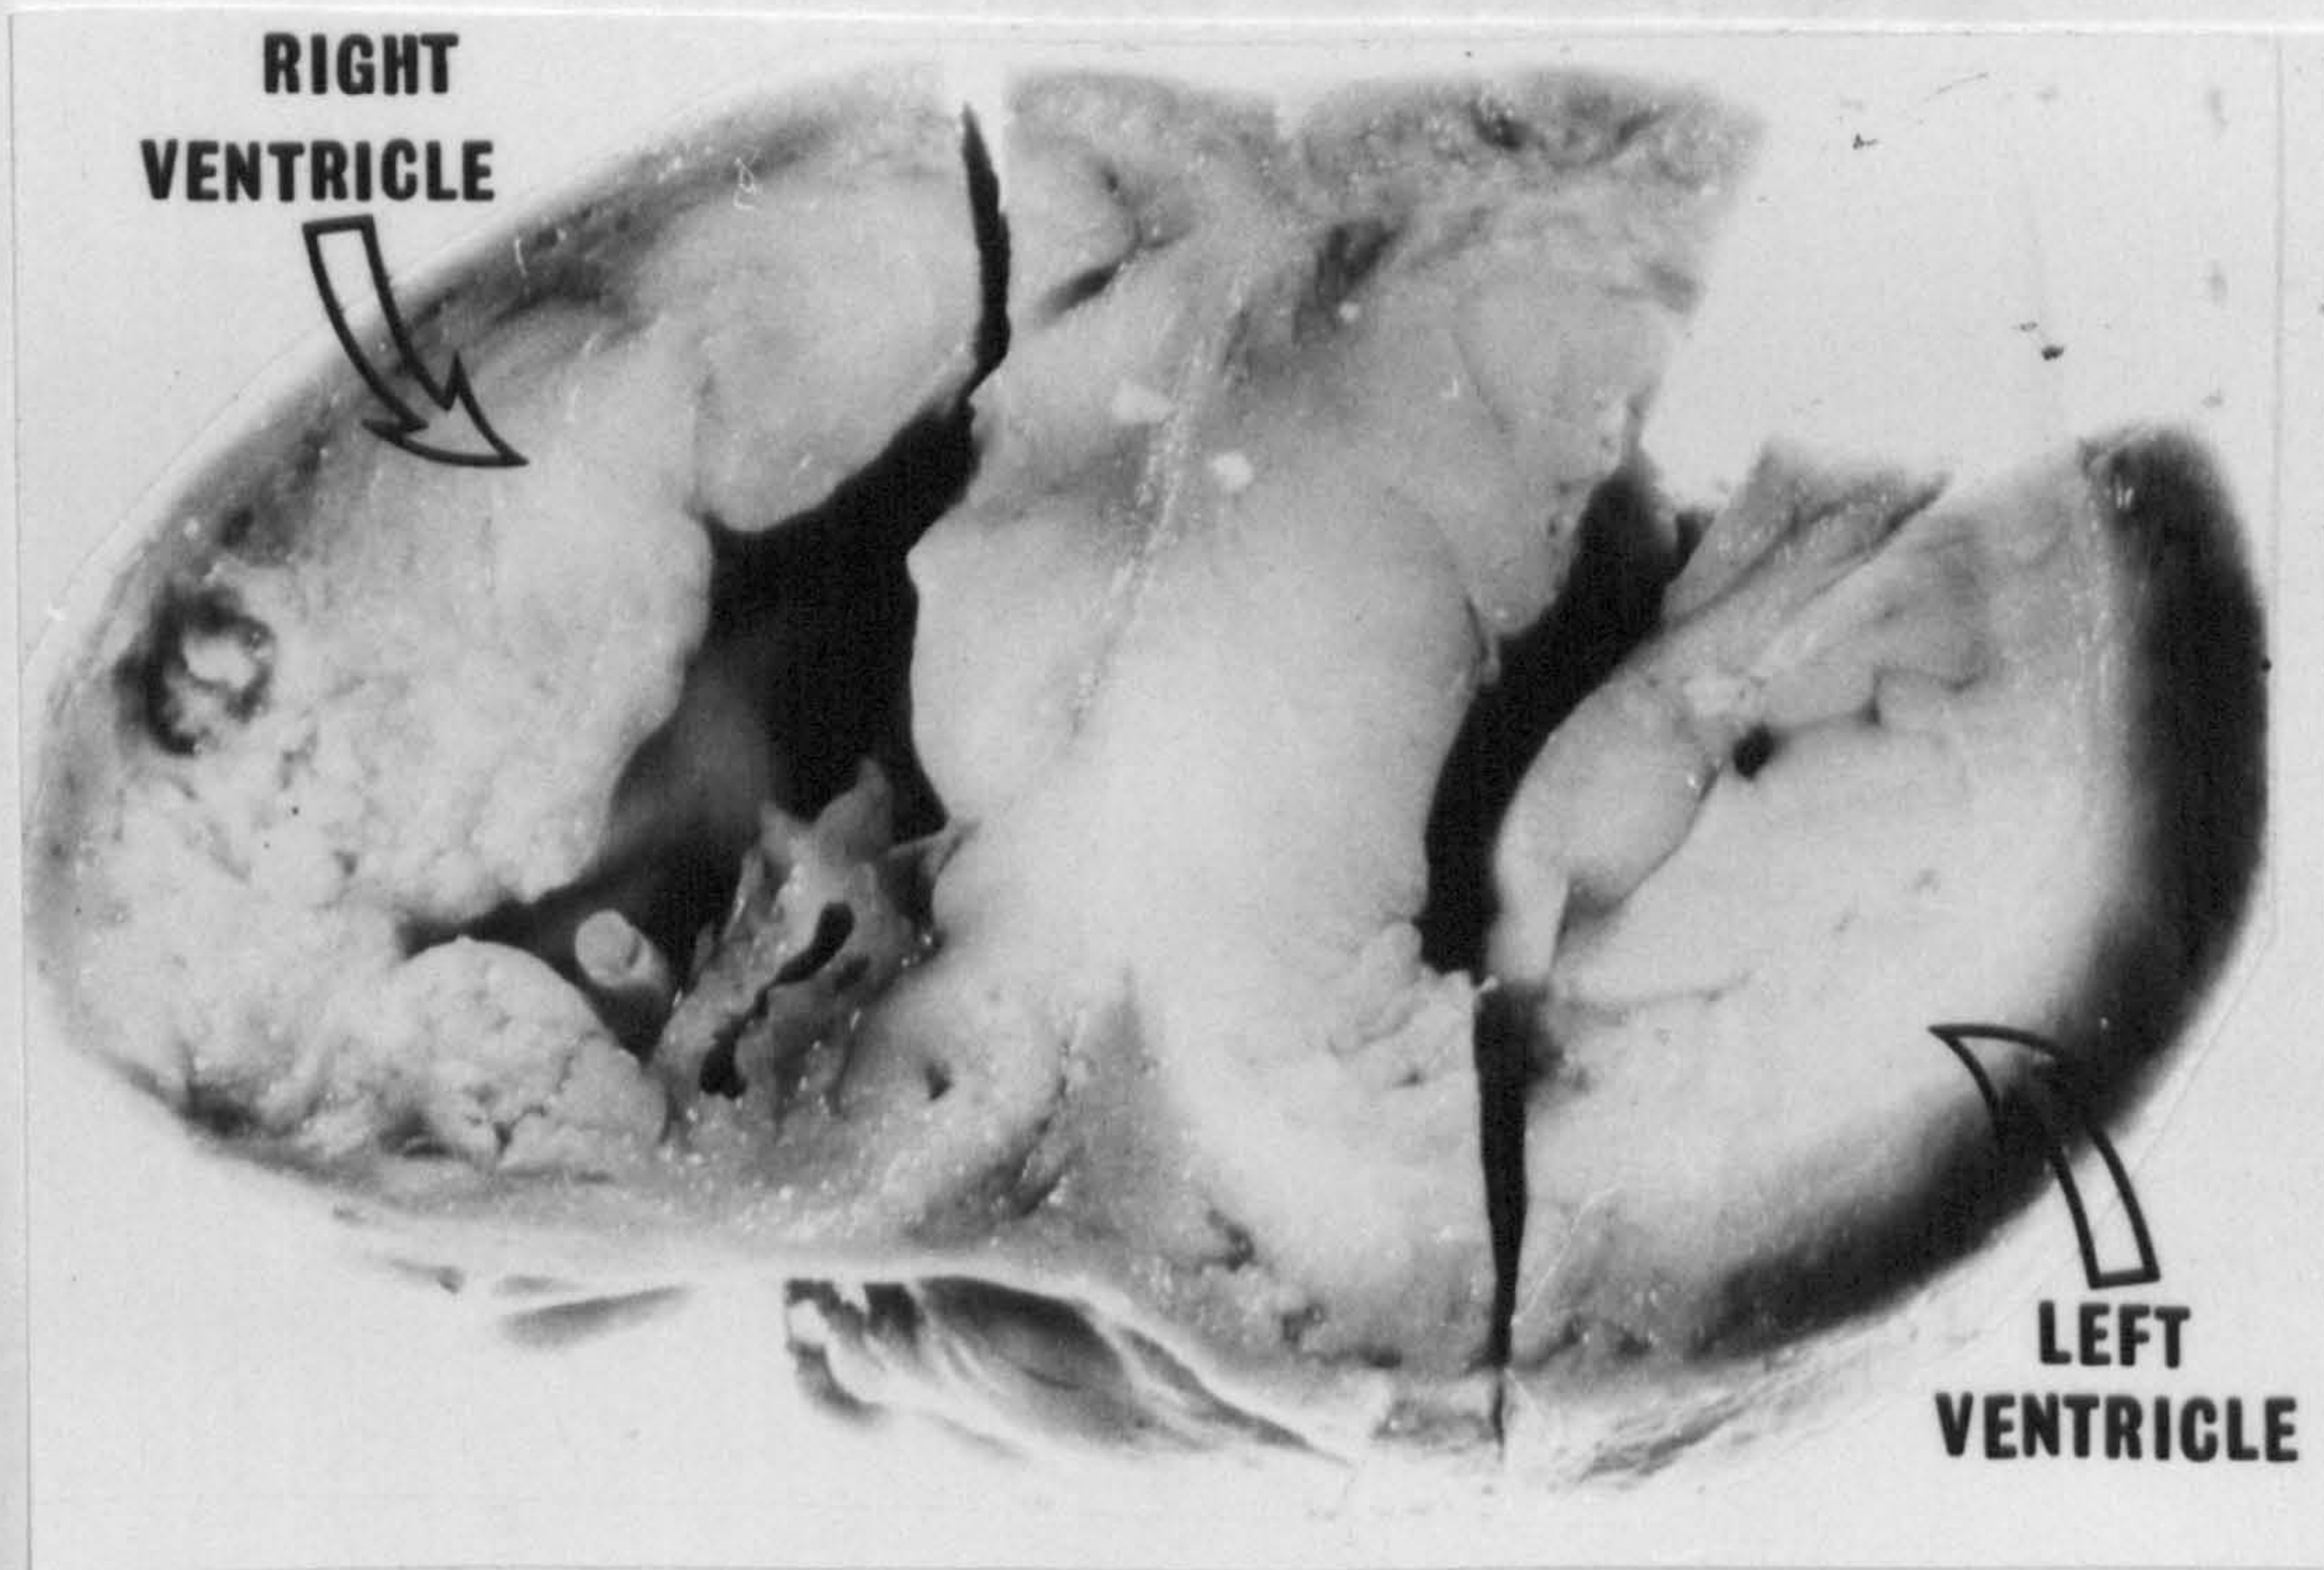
Case 3. The fetal heart has been cut in short axis through the body both ventricular chambers. The thickening of the septum and left ventricular wall can be seen. The left ventricular cavity is slit-like as it appeared on the echocardiogram.
